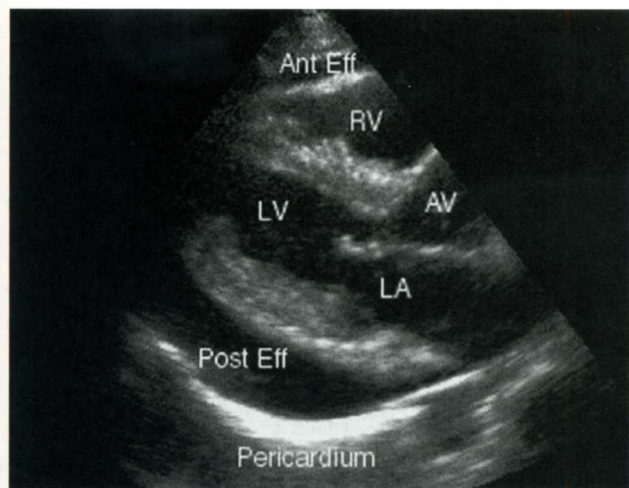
Cardiac tamponade. Parasternal long-axis view with diastolic collapse of right ventricle. (Courtesy of James Mateer, MD)
